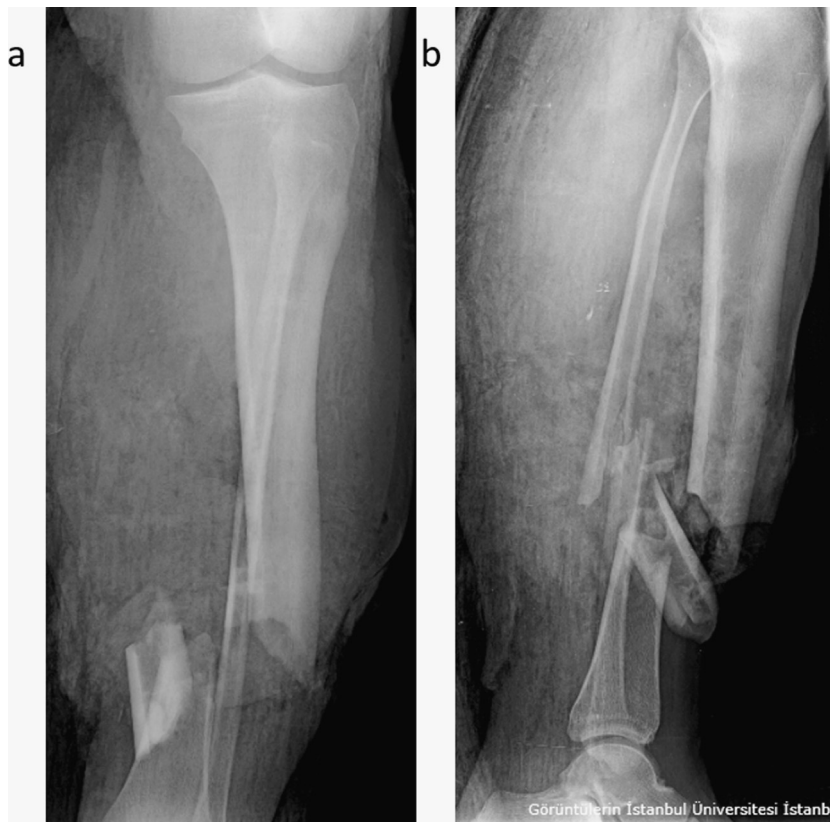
a and b anteroposterior and lateral radiographies of the left crus display AO/OTA 42-C2 tibia complex segmental fracture.
